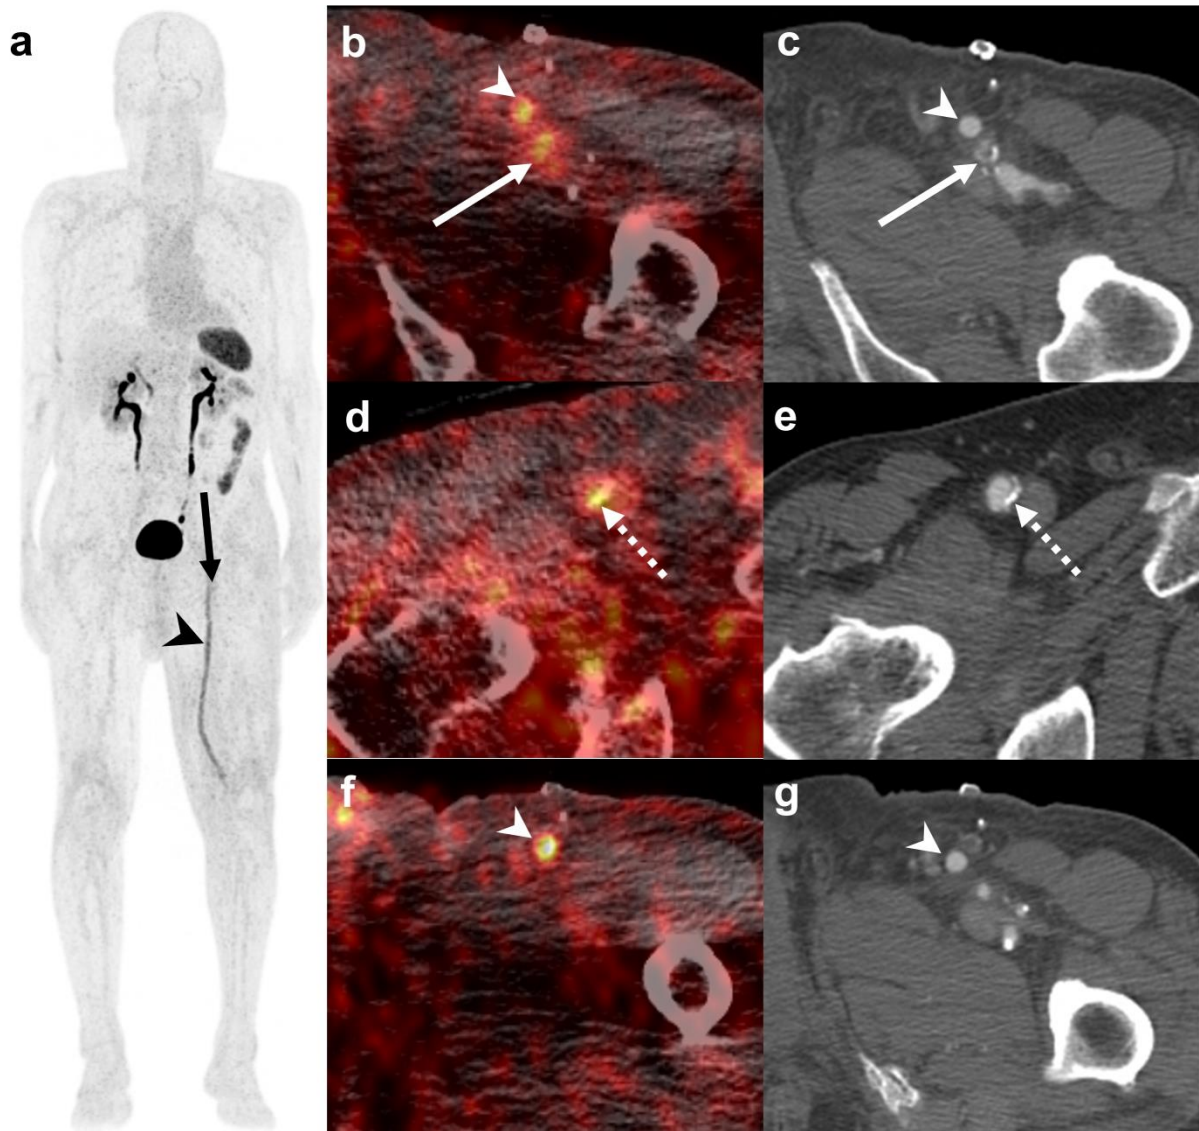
^{18}F -GP1 PET/CT images of a 76-year-old man with bypass surgery and stent placement. Anterior maximum intensity projection and transaxial images of ^{18}F -GP1 PET/CT at 120 min after injection show a focal increased uptake in the left superficial femoral artery (a and b; arrows), which corresponds to the total occlusive lesion with calcified plaque (c). Additional positive ^{18}F -GP1 uptakes are observed in the right common femoral artery with calcification (d and e; dotted arrows) and left femoral popliteal bypass graft (a, b, c, f and g; arrow heads), which was performed 3 days before ^{18}F -GP1 PET/CT.
